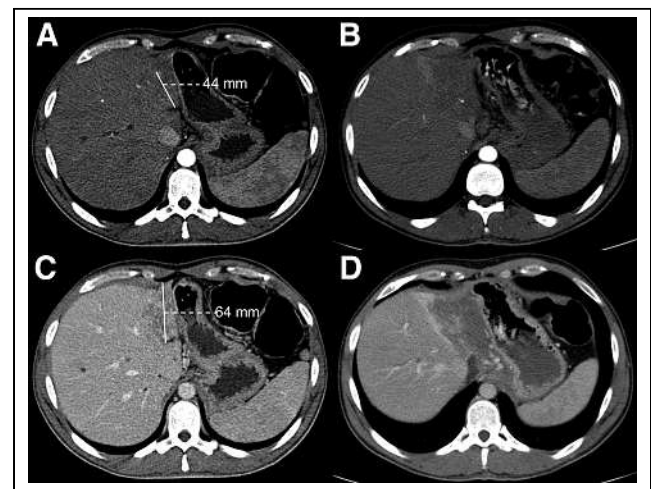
Extensive intrahepatic edema and necrosis after left lobar treatment with ⁹⁰Y-glass microspheres. Shown are multiphase contrast-enhanced CT at baseline (A and C) and 3 mo after treatment (B and D). At baseline, primary tumor invades left liver lobe on portal venous CT (C) and shows enhancement in arterial phase (A). Posttreatment images show intrahepatic edema and necrosis, masking tumor for RECIST 1.1 assessment. However, disappearance of arterial enhancement suggests complete response according to modified RECIST.
